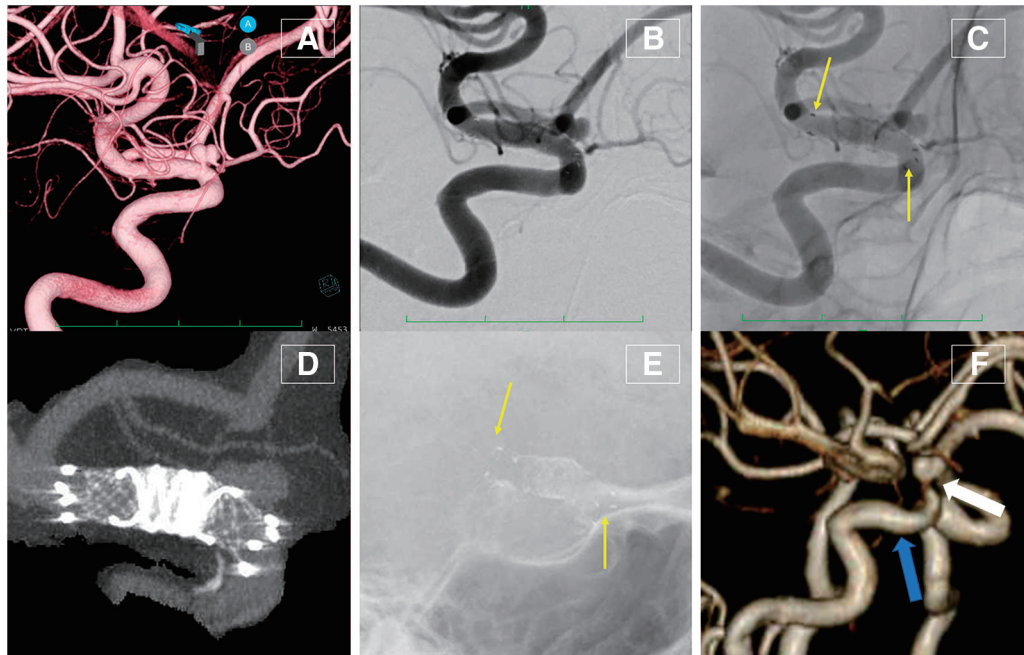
Angiogram obtained 12 months after the treatment demonstrated a complete aneurysm. (A) 3D reconstruction of DSA and (B) DSA. Distal migration and shortening of the FRED stent were revealed, resulting in incomplete coverage of the aneurysm neck. The yellow arrows indicate the distal and proximal flared ends of the FRED, respectively. (C) Digital angiogram and (D) 3D reconstruction of cone-beam CTA. Lateral skull X-ray taken 1 day after the treatment demonstrated that the migration of the stent had already occurred. The yellow arrows indicate the distal and proximal flared ends of the FRED, respectively (E). Signal loss due to the stent artifact in MRA 1 day after the treatment did not span the portion where it was originally deployed (blue arrow) but began at the proximal neck of the aneurysm (white arrow), indicating that the migration of the stent had already occurred (F). FRED: flow-redirection endoluminal device
